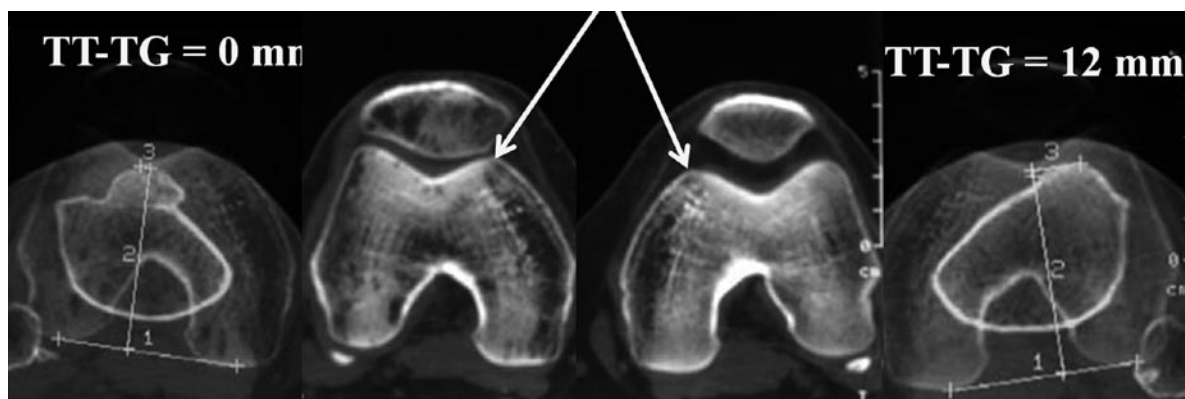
Iatrogenic medial arthritis after hypermedialization. The CT scan allowed to compare involved and none involved knee. The cartilage analysis is optimize if combined to arthro CT
